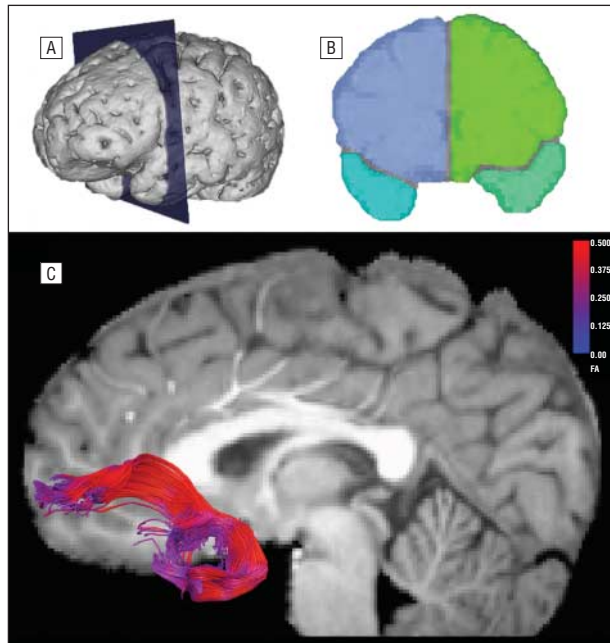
Region-of-interest placement for delineation of the bilateral uncinate fasciculus. A, The most posterior coronal section that showed clear separation of the frontal and temporal lobes bilaterally was identified in each individual. B, Bilateral frontal and temporal lobe seed regions of interest were then manually drawn on this section. The Boolean *AND* term was used to select only fibers that crossed through both the temporal and frontal seed regions of interest for tract-based analysis. C, Uncinate fasciculus tracts overlaid on an anatomical T1-weighted image for a single individual. FA indicates fractional anisotropy. For a 3-dimensional rendering, see the video.
